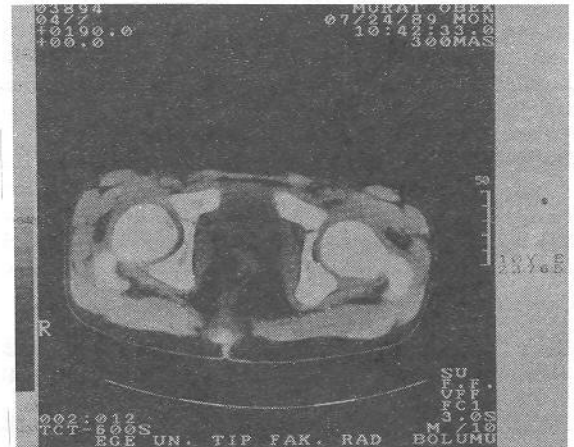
CT showing centrally located neorectum between the sufficient muscle complex.
